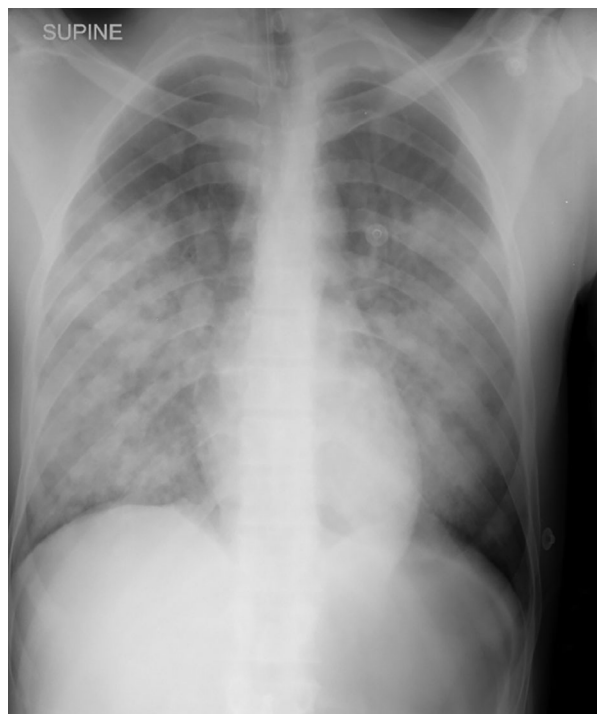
The chest radiograph taken on admission showing diffuse alveolar infiltrates in keeping with non-cardiogenic pulmonary oedema / acute respiratory distress syndrome. (admission)
